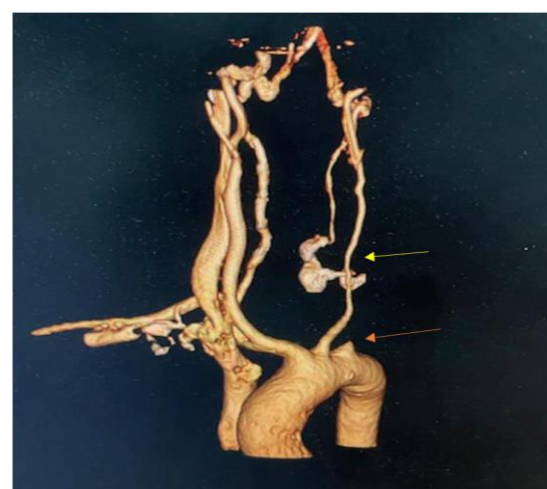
CT angiography of the supra-aortic trunks, 3D reconstruction, showing stenosis of the left common carotid artery (yellow arrow) and thrombosis of the left subclavian artery (red arrow) (Case 1).
